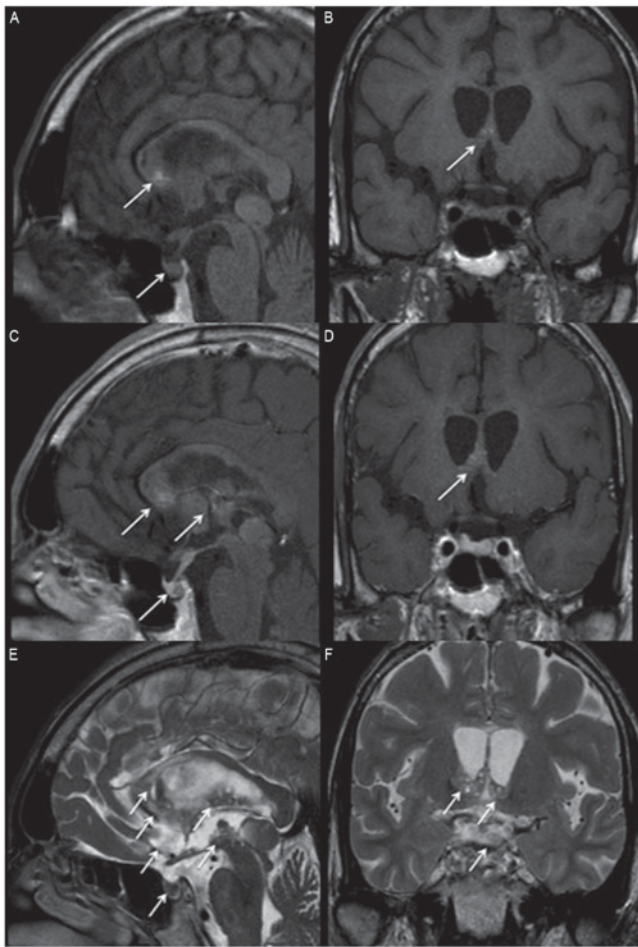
Magnetic resonance imaging of sella prior to treatment. Heterogeneous lesions are indicated by arrows and are present in the basal ganglion, hypothalamus, corpus callosum, posterior hippocampus, pineal gland, stalk and posterior pituitary gland in (A) non-contrast sagittal, (B) coronal, (C) contrast sagittal and (D) coronal T1 weighted images, as well as (E) T2 weighted sagittal and (F) coronal images.
